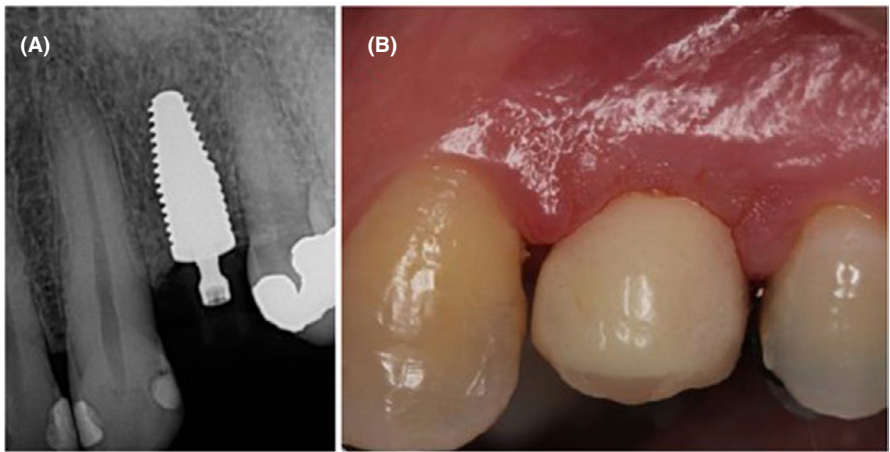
(A–B) Patient 2 postsurgical with immediate loading—periapical x-rays (A) and lateral photograph (B)
